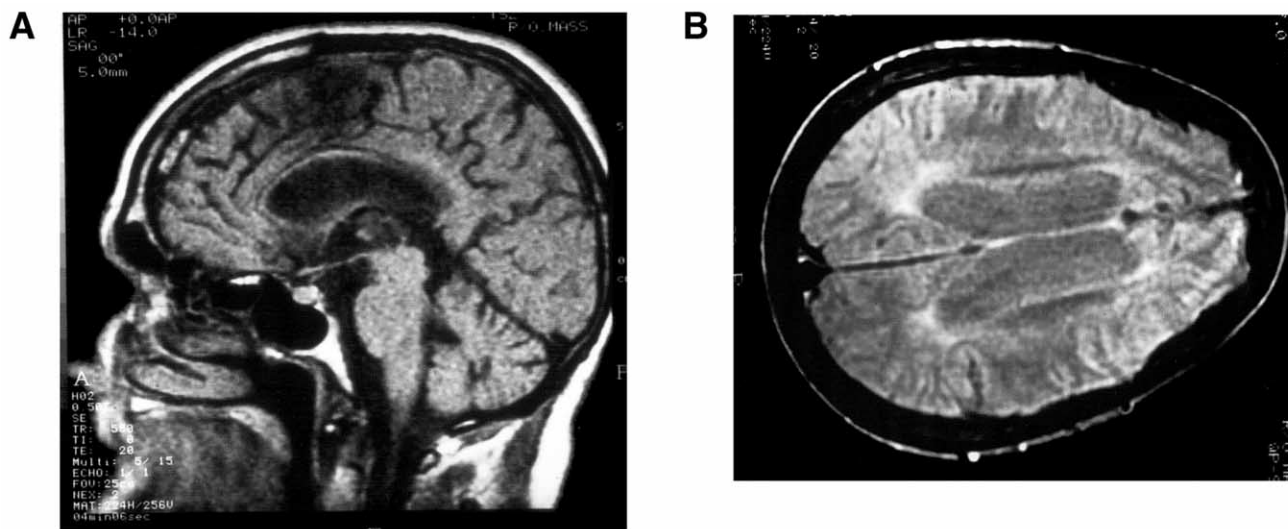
MRI of patient 17, showing thin corpus callosum and cerebral atrophy (A) and periventricular white-matter hyperintensity (B)
